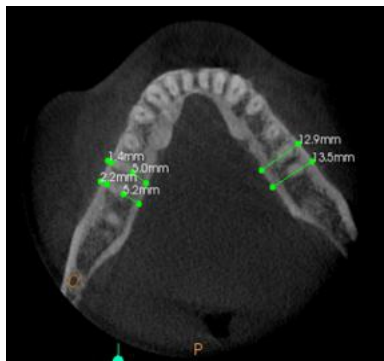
Examples of the 3 different measurements taken for both the mesial and distal roots of the mandibular first molar on (Axial View) CBCT Scan.
